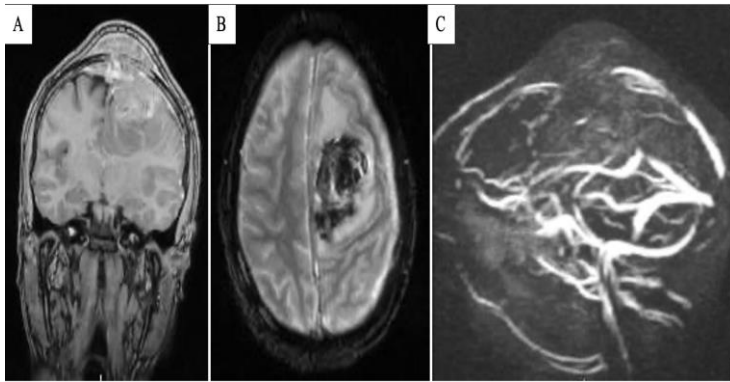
Brain contrast-enhanced MRI and MRV. A: Coronal view demonstrating a heterogeneously enhancing parafalcine tumour with a dural tail. B: Susceptibility-weighted imaging showing blooming consistent with intratumoural haemorrhage. C: MRV demonstrating compression and displacement of the middle third of the superior sagittal sinus without definite intraluminal invasion.
